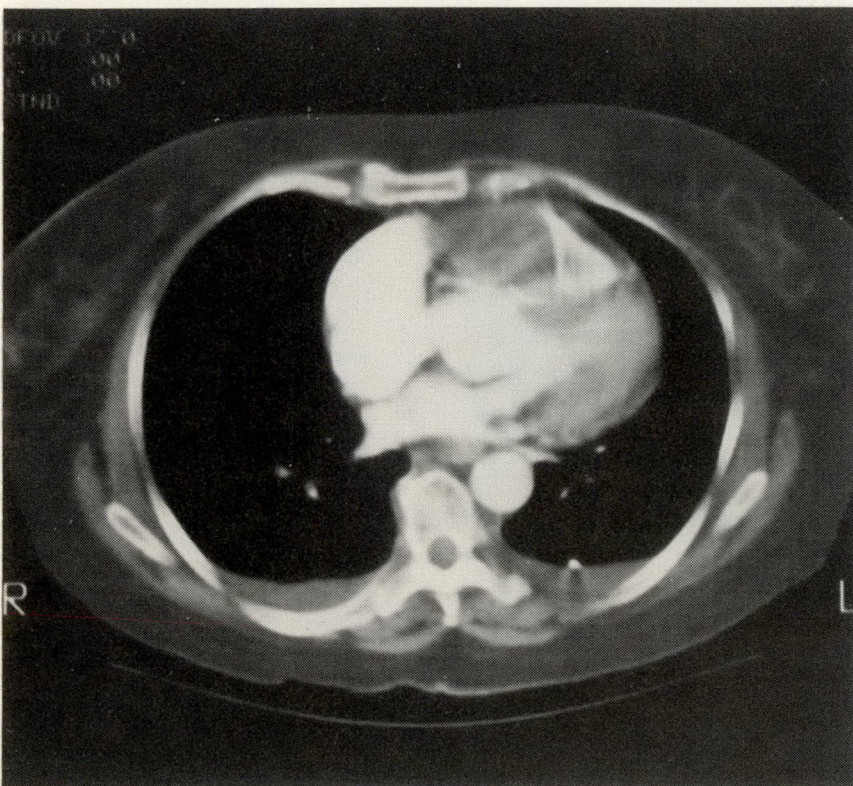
Contrast computed tomogram of thorax shows filling defect in right atrium and right ventricle.
